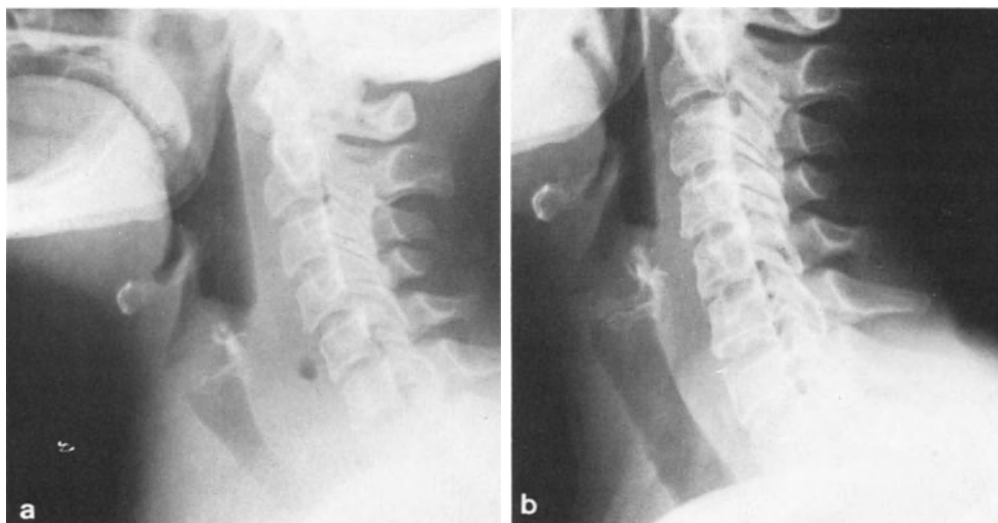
a Massive carcinoma lying in front of and behind the trachea and compressing it (12. 3. 74). b Normal appearance is restored after X-ray treatment (6. 5. 74)
